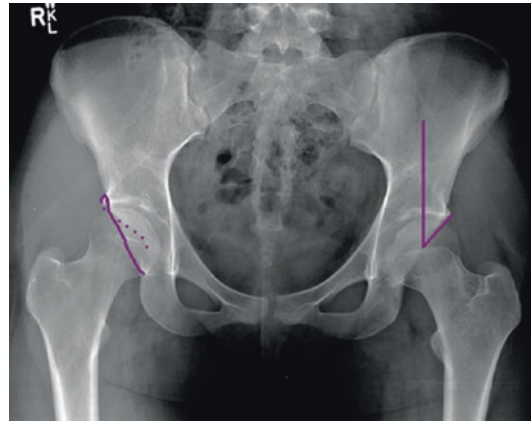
AP pelvis X-ray demonstrating acetabular retroversion creating crossover sign (right hip) and center-edge angle (left hip)
